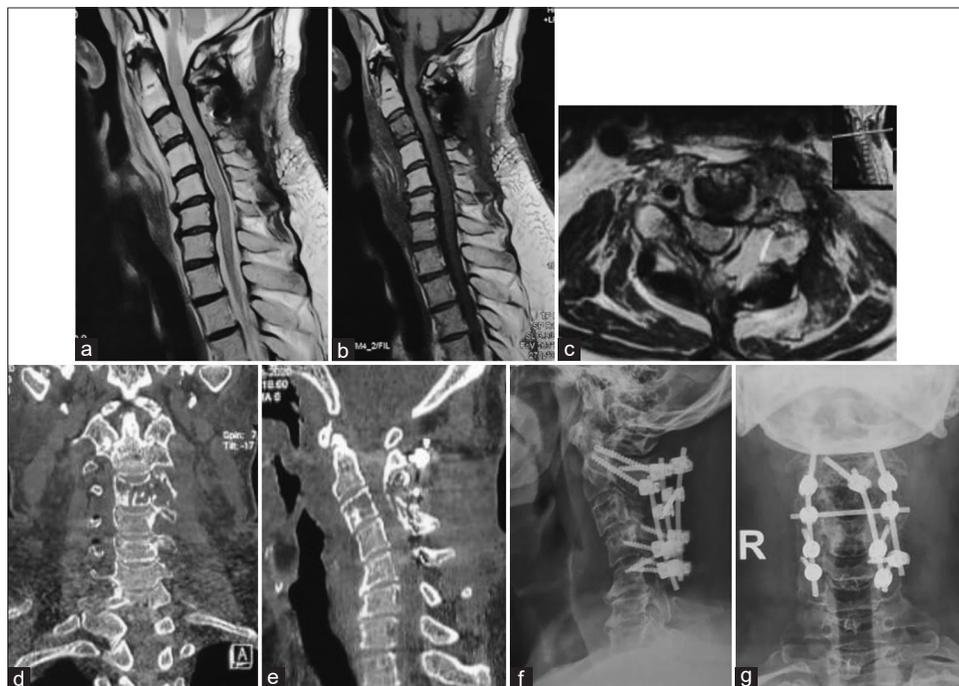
Anteroposterior and lateral radiographs in the immediate post-operative period showing resection of posterior elements and laminectomy at C3 and fixation with a novel three rod construct utilizing C2 and C4 (left) pedicle screws and C2 laminar screw with C4, C5 lateral mass screws.
